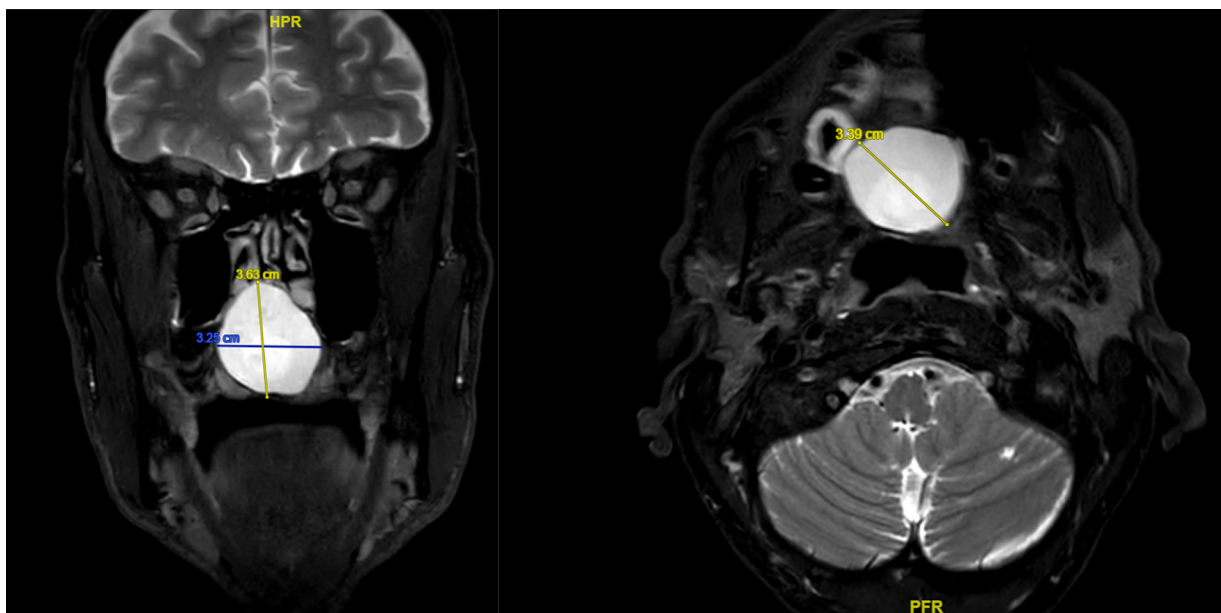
MRI T2 coronal and axial view, the lesion appears hypersignal, liquid, measuring 36 mm by 34 mm.
